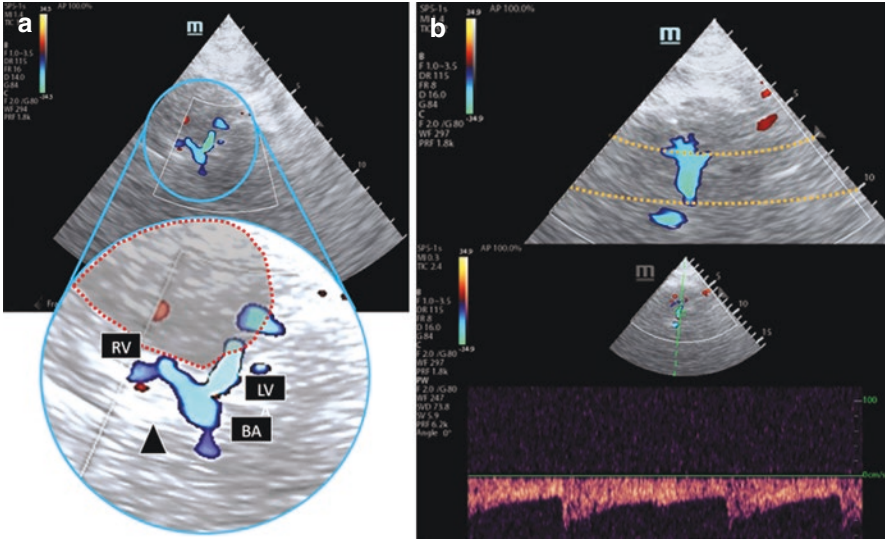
(a) Transforaminal insonation at vertebral arteries plane. The blue circle is magnified to better understanding of the insonated structures. See how both vertebral arteries find each other to follow as the basilar artery. Red dots with shades area demarcate the foramen magnum (hypoechoic), the black triangle indicates the location of the clivus (hyperechoic). (b) Complete insonation of the basilar artery in depth range between 70 and 100 millimeters (area between orange dotted lines), and spectral Doppler showing basilar flow velocity. (Author: Jorge Carrizosa)
